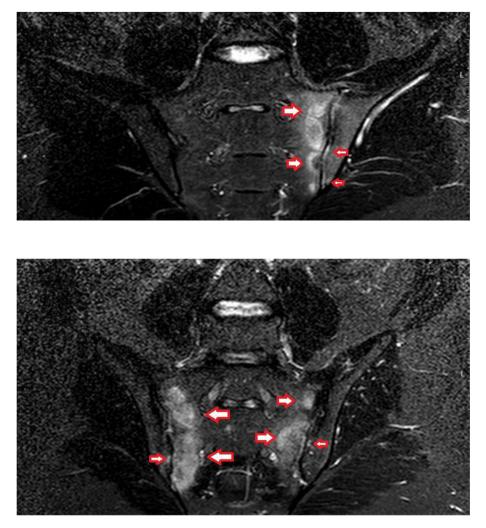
Bone marrow edema on MRI of the sacroiliac joints. Two examples of bone marrow edema detected in the sacroiliac joint of patients diagnosed with axial spondyloarthritis. Upper panel: unilateral bone-marrow edema in the left sacroiliac joint. Lower-panel: bilateral bone-marrow edema in the sacroiliac joints. Patients gave written consent for use of the image for educational purposes.
